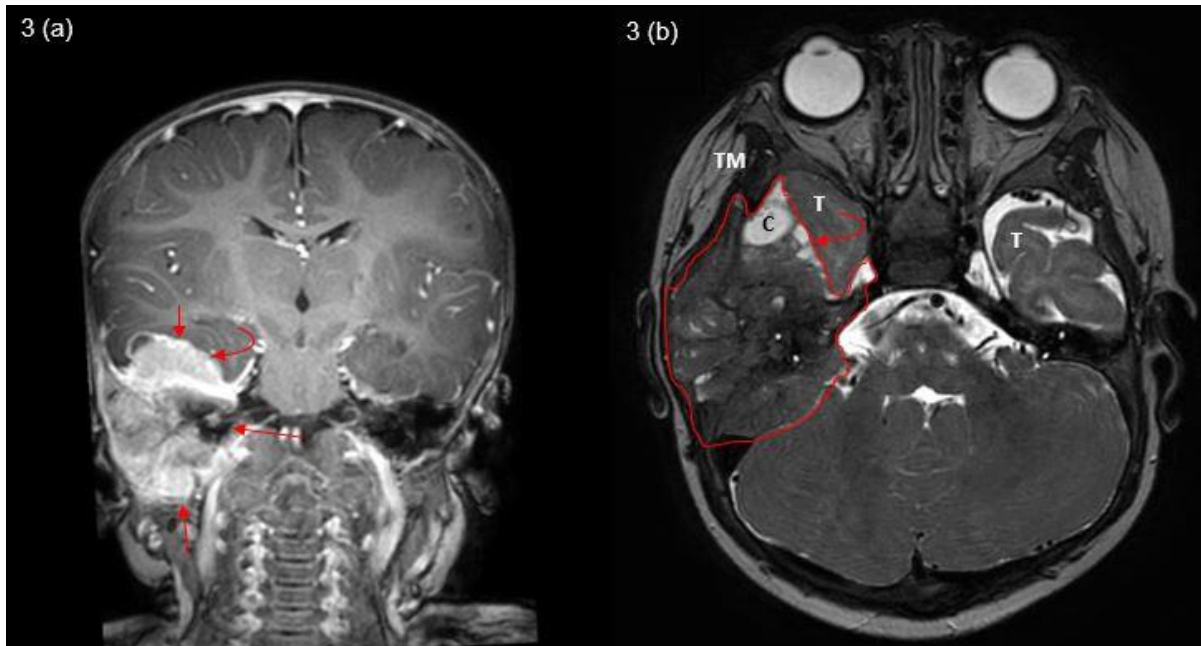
T1-weighted MRI with gadolinium (3a) and T2-weighted (3b) images of the brain showing an expansile (outlined) destructive heterogeneous intensely enhancing mass (arrow) adjacent to the right temporalis muscle (TM) and involving the mastoid as well as petrous bones with a small cystic component (C) at anterior aspect and intracranial extension into regional temporal lobe (T) (curved arrow).
